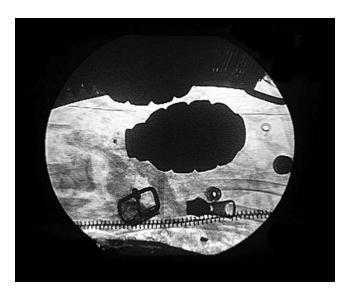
Radiography is also useful for identifying weapons, ammunitions, or unused explosives within pockets or layers of clothing. Pictured here are two grenades stuffed into a pocket. These grenades were not found in the field at the time of excavation, but later after being transported to the morgue and scanned with a fluoroscope (ICTY).
